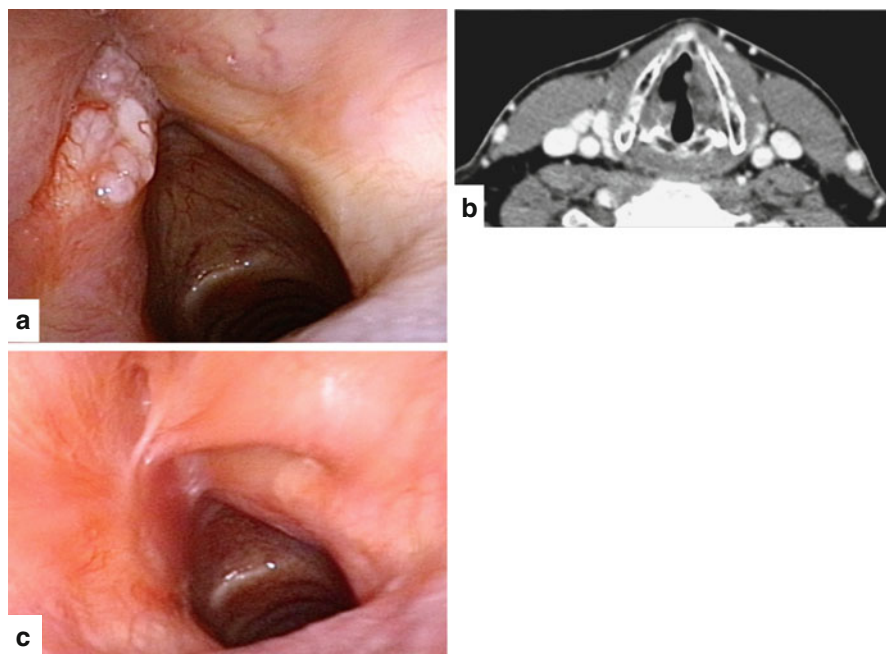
(a) Endoscopic view of a squamous cell carcinoma (SCC) of the left vocal fold. (b) Preoperative CT scan of the same lesion showing the invasion of the left anterior paraglottic space. (c) Endoscopic view 3 years after TLM
